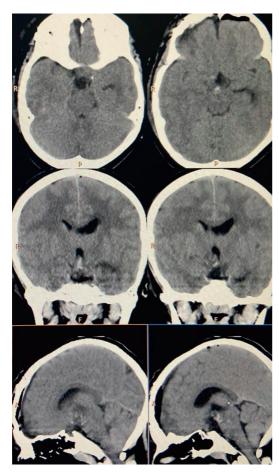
Postoperative computed tomography scan of the head showing complete excision of the lesion (A).
